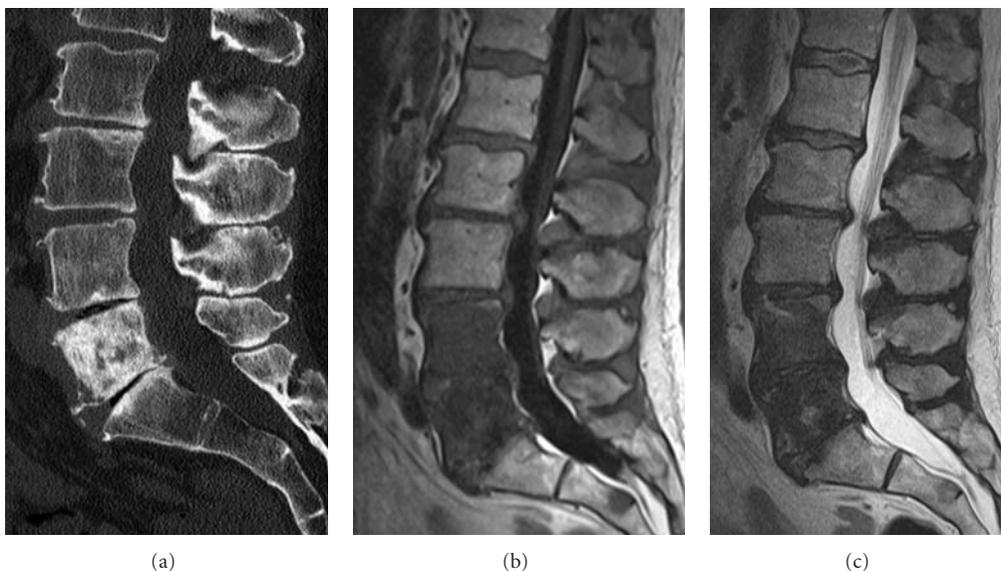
Sagittal CT reformation of the lumbar spines (a) shows a large sclerotic lesion nearly completely involving the L5 vertebral body. Sagittal T1-weighted (b) and T2-weighted (c) images show abnormal hypointense marrow signal in not only the L5 vertebral body but also the L4 vertebral body, corresponding to blastic metastatic lesions.
